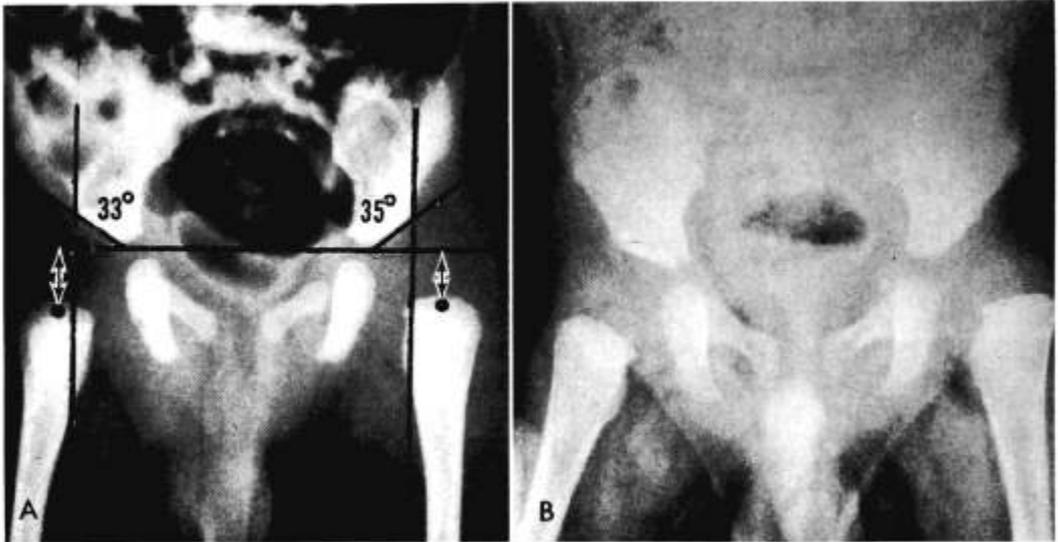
Case 6. The left hip on this male infant could be displaced upon examination at age 3 weeks. The roentgenogram (A) was taken at 3 days of age and shows normal acetabular indices and the femoral "beak" lying medial to the vertical line. Suggestive unilateral "shallowness" and foreshortening of the "H" line are present, despite the slight rotation in the film. The roentgenogram (B), taken at 4 months of age, shows dislocation of the left hip. Clinically also, the hip was dislocated, and the Ortolani sign of "entry" could be elicited.
